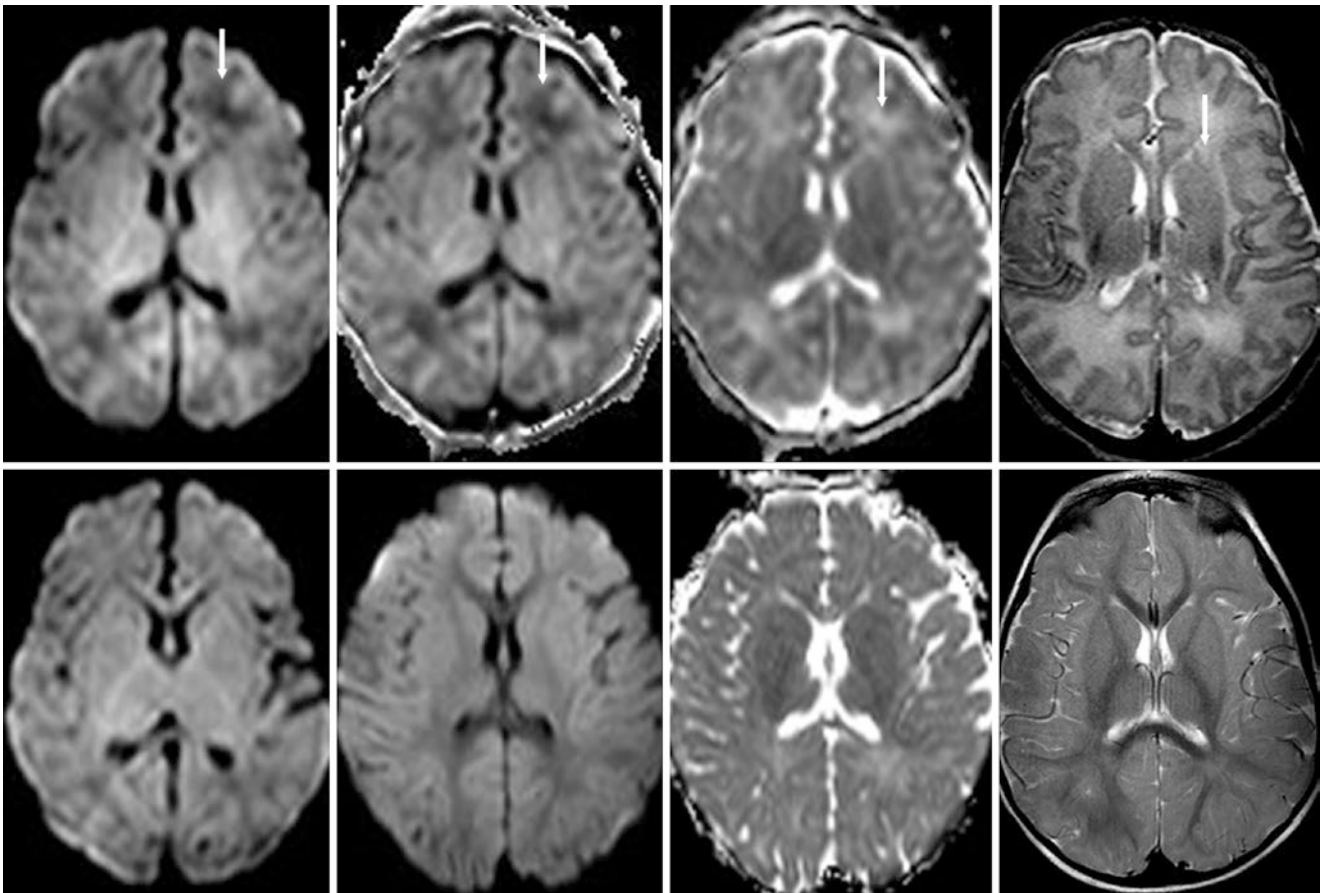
A 7-day-old term infant with weakness had a normal 3T MRI. *Top row*: On DWI (*left*) and exponential DWI (*left middle*), which removes the T2 component of the DWI, there was asymmetric low signal (*arrows*) of left frontal PVWM, which was mildly bright on the ADC map (*right middle*) and SE T2WI (*right*). *Bottom row*: At 2.5 months of age, the gray matter and white matter are isointense on DWI
